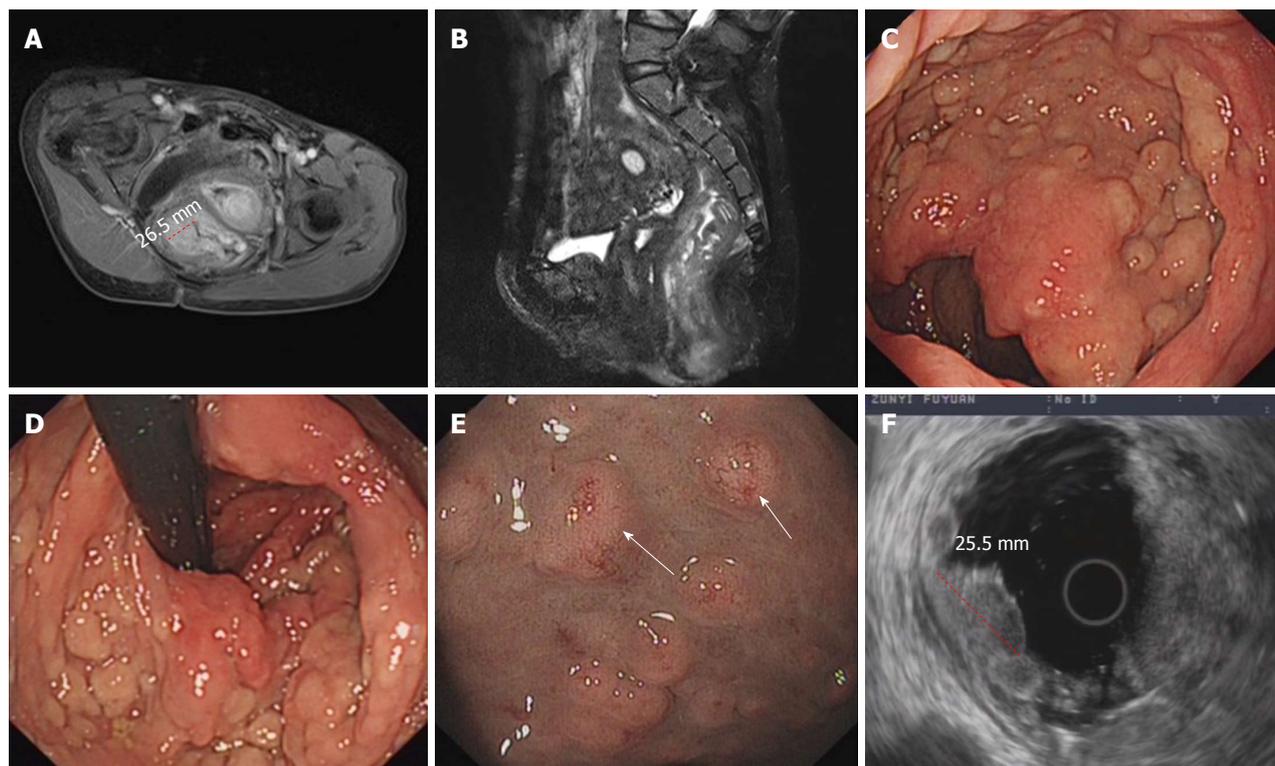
Imaging, endoscopy and endoscopy ultrasonographic findings of multiple rectal neuroendocrine tumors in the patient. A and B: Magnetic resonance imaging (red dotted line marking the widest point of the tumors, measuring approximately 26.5 mm); C and D: Endoscopic manifestations; E: Blood vessels were apparent on the surface of the nodules under the NBI (neuroendocrine tumors marked by the white arrow); F: Endoscopic ultrasonography of the multiple rectal neuroendocrine tumors (red dotted line marking the widest point of the tumors, measuring approximately 25.5 mm). NBI: Narrow-band imaging.
